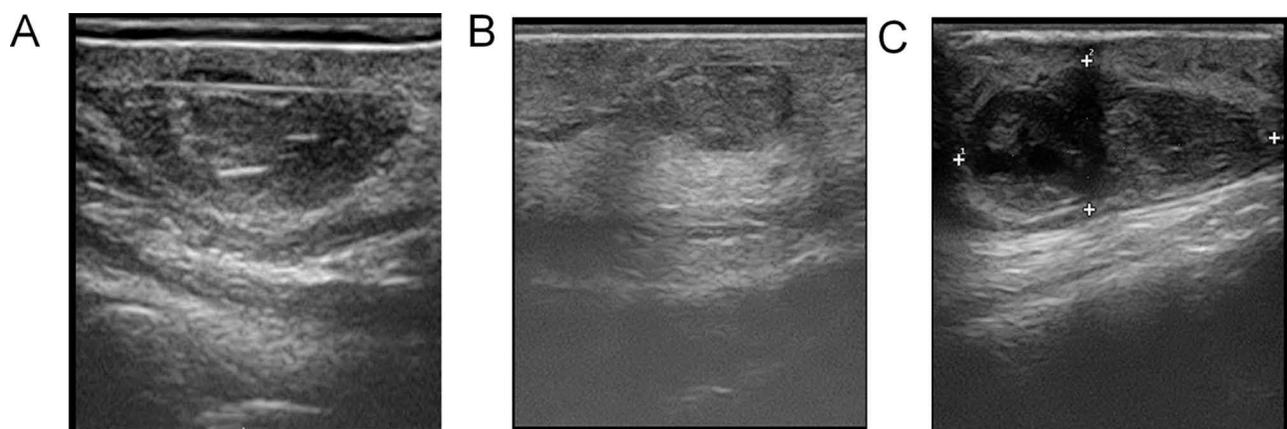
Ultrasonic Features of Trichofolliculoma: Inhomogeneous Low Echogenicity, Cystic Structures, and Posterior Acoustic Enhancement. (A) Short linear hyperechoic elements observed within the lesion. (B) Inhomogeneous low echogenicity with discernible cystic structures present. (C) Posterior acoustic enhancement of the nodule noted.
